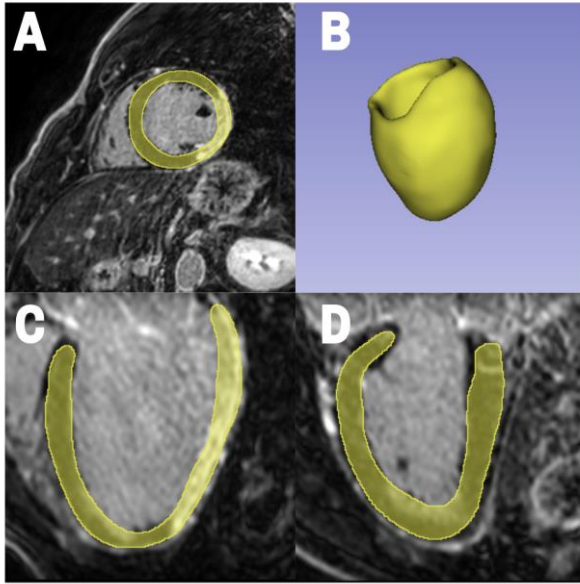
Images from the 3DSlicer platform. All of them correspond to our segmentation of the left ventricle from an MRI. A: Axial plane; B: 3D geometry; C: coronal plane; D: sagittal plane.
